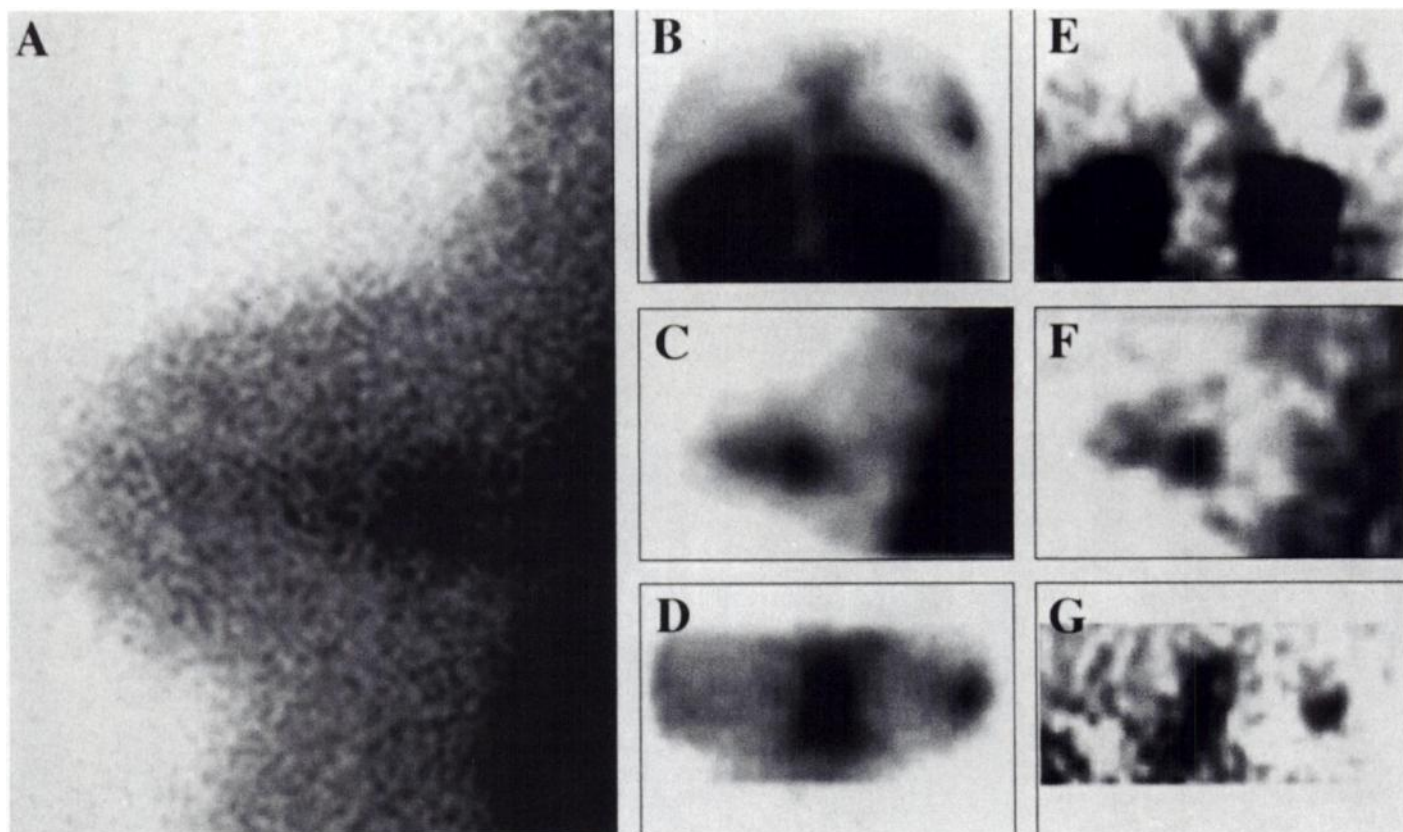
Ductal infiltrative carcinoma (pT1b) on basis of extended (3-cm) carcinoma in situ. (A) Planar lateral SMM demonstrated focal sestamibi uptake that could not be delineated from chest wall. Additional transverse (B, E), sagittal (C, F) and coronal (D, G) SPECT slices enabled improved assessment of tumor extent and localization. Diagnostic quality of ISA-SPECT (B–D) was superior due to significant reconstruction artifacts of FBP-SPECT (E–G).
